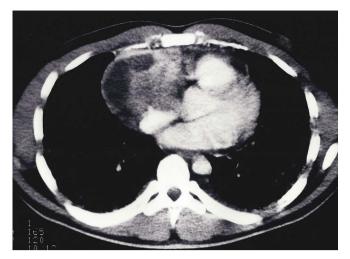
CT chest with contrast showing a non-homogeneous mass in the anterior mediastinum, abutting the heart.
